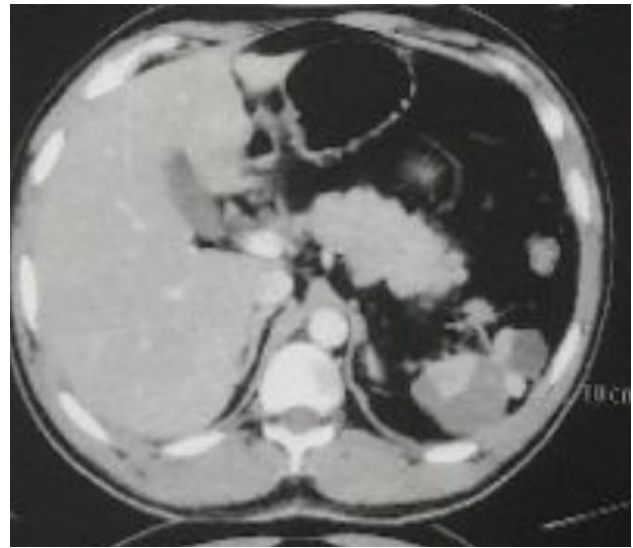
CT showing thrombus at celiac trunk (white arrow).
